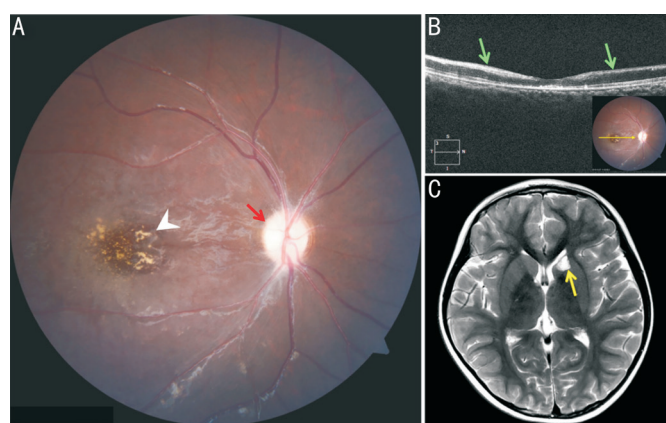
FP (A), OCT (B) and cranial MRI (C) results after 2-month treatment A: The red arrow pointed to the pale optic disk and the white one pointed to the fading cherry erythema; B: The green arrow pointed to the regression of the retinal edema; C: The yellow arrow showed partial resorption of the cerebral hemorrhage. FP: Fundus photography; OCT: Optical coherence tomography; MRI: Magnetic resonance imaging.
